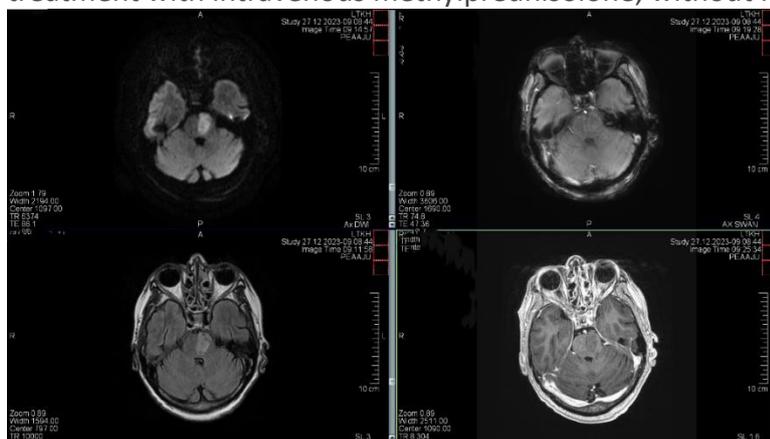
Second MRI scan showing ischemic lesion in the brainstem on the left.
